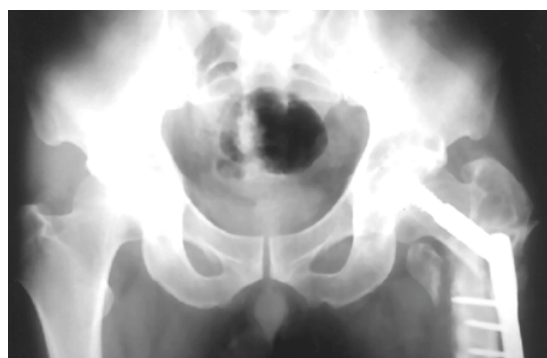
Anteroposterior radiograph of the both hip. At the time of initial nonunion state, there are screw failure and nonunion
